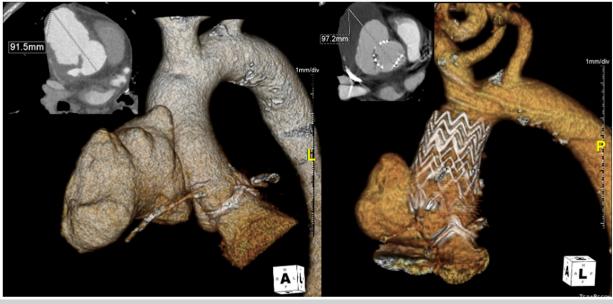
Intraoperative angiography with preoperative axial computed tomography (CT) detail and postoperative three-dimensional CT reconstruction of focal type A aortic dissection (TAAD) treated with ascending thoracic endovascular aortic repair (TEVAR) with two abdominal cuffs.
